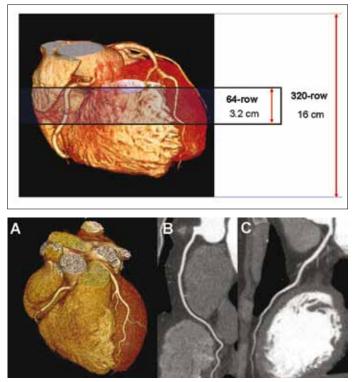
Single heartbeat 320-row CTA in a 39 year old female with atypical chest pain and with positive family history for CAD. CTA ruled out the presence of CAD and the patient was safely discharged. Panel A shows a three-dimensional volume rendered reconstruction of the heart. Panel B shows a normal right coronary artery. Panel C shows a normal left anterior descending coronary artery.
